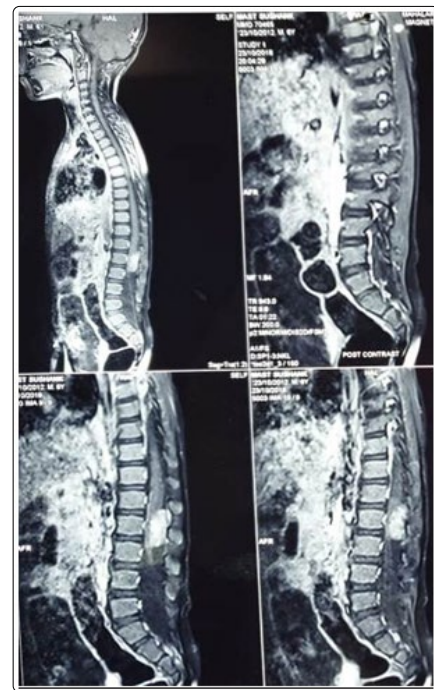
T1 Contrast MRI Saggital sections showing heterogeneously enhancing lesion with ill defined rim located in L1 and L2 region intradural-extramedullary lesion
